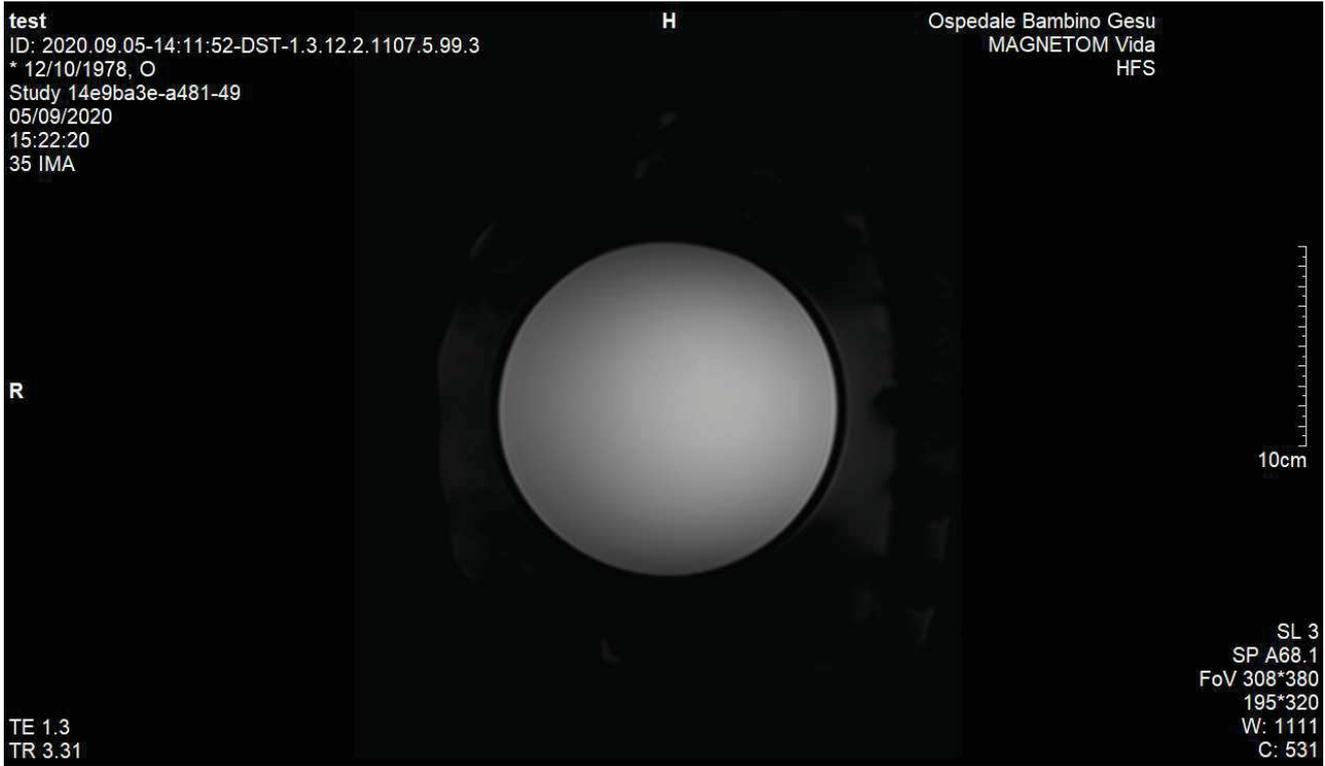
MRI scanned image
